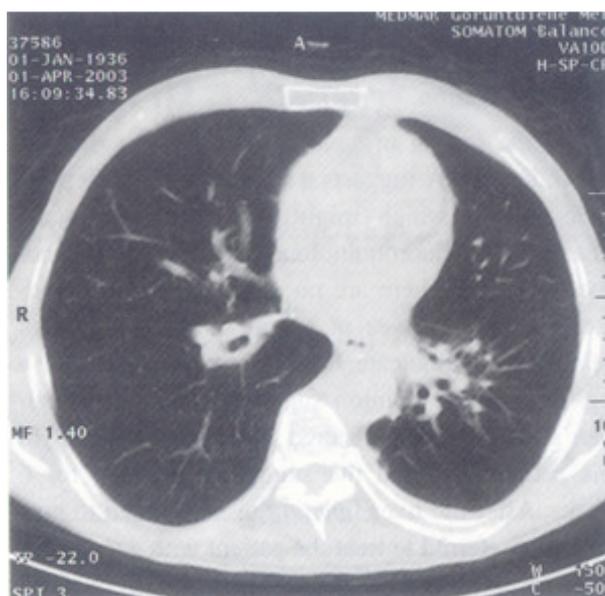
Control CT of thorax after 2 years showing resolution of the interstitial lesions.
